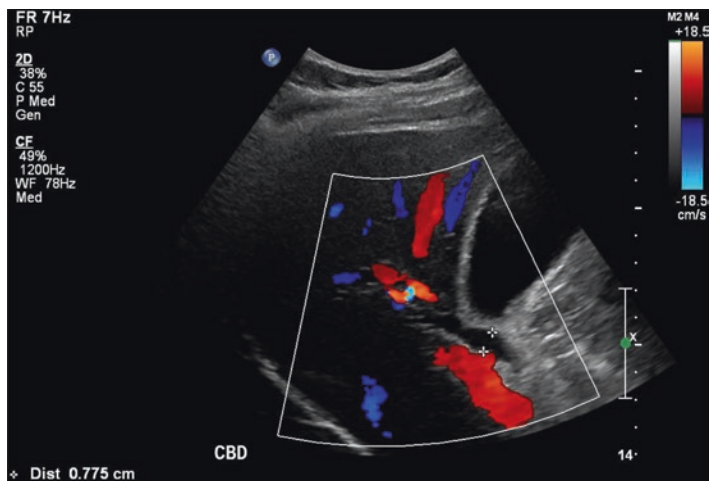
Transabdominal ultrasonography revealing a dilated common bile duct (8 mm) but no choledocholithiasis
